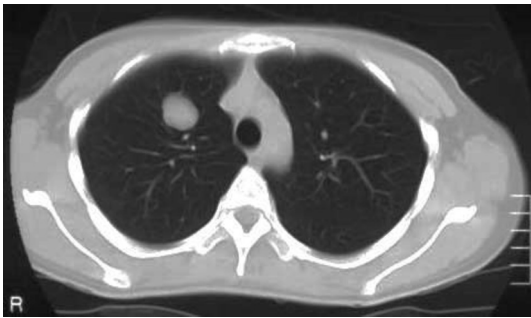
Chest CT showing a well-defined nodule in the right upper lobe.
